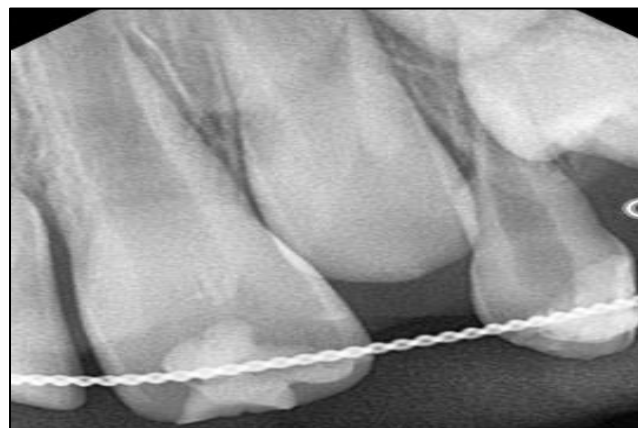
(a): Radiograph Showing Splinting
